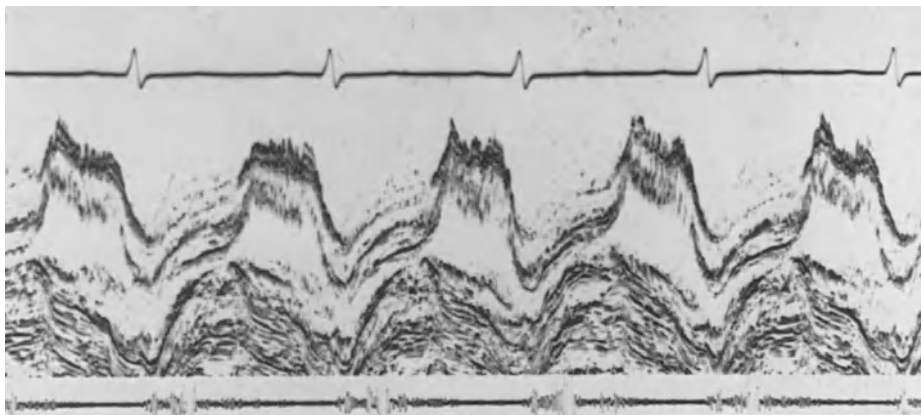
M-Mode echocardiogram showing fluttering of mitral valve leaflets in aortic regurgitation.
